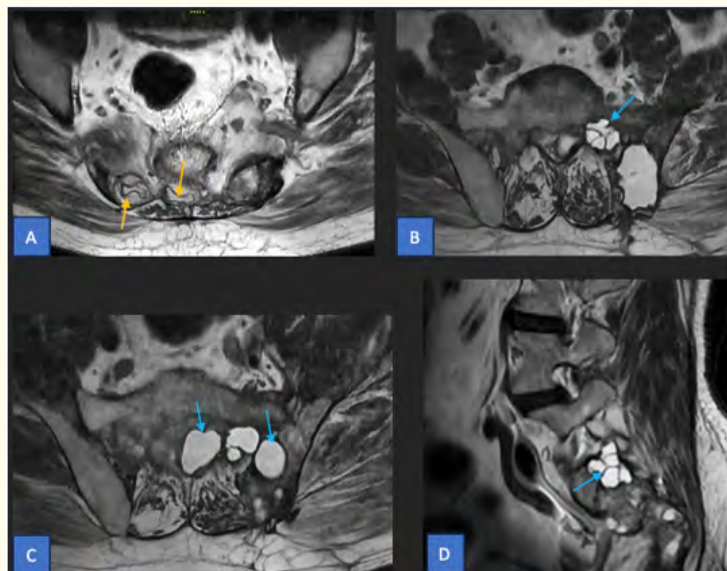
Axial (a-c) and sagittal (d) T2-weighted MRI images demonstrating bilateral hyperintense, multilobulated cystic lesions involving the sacroiliac joints (blue arrows). On the right, the presence of the characteristic water lily sign is noted (yellow arrows), corresponding to the detachment of the endocyst membrane and its floating within the cystic fluid.
